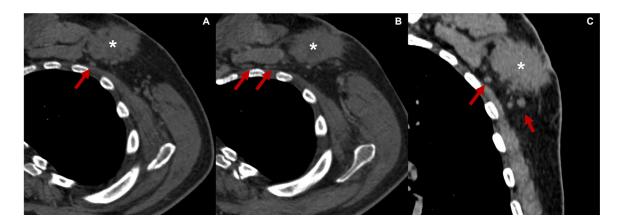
Body CT scan (Philips iQon 256 Dual CT scan), unenhanced phase in axial (A, B) and coronal view (C) of the left anterior chest wall and axilla. The images show the mass in the left breast (white star) and multiple sub-centimetric lymph-nodes (red arrows) at the I, II, and III levels of the left axilla.
